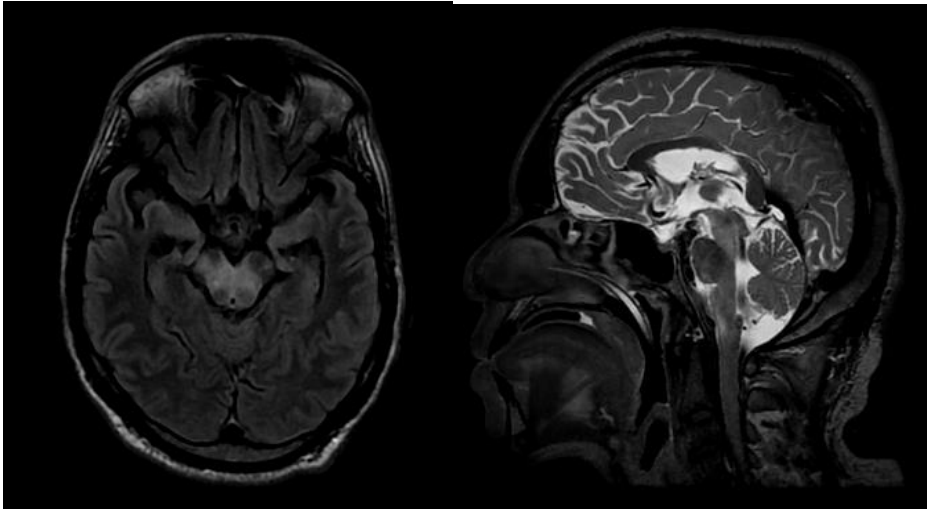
Repeated contrast enhance MRI.
